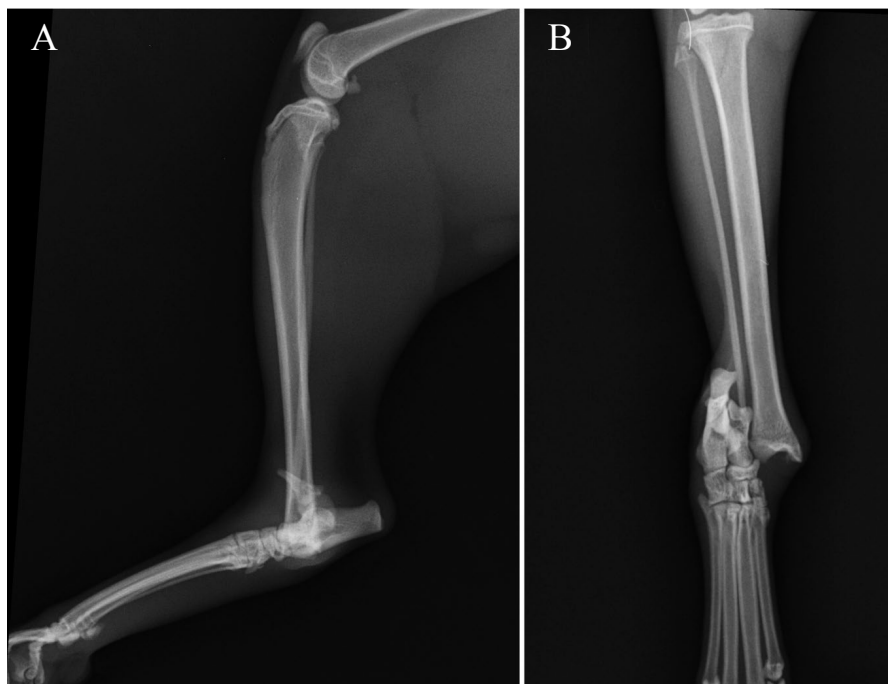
A. Lateral and B. Antero-posterior preoperative radiographs of tarsocrural luxation
